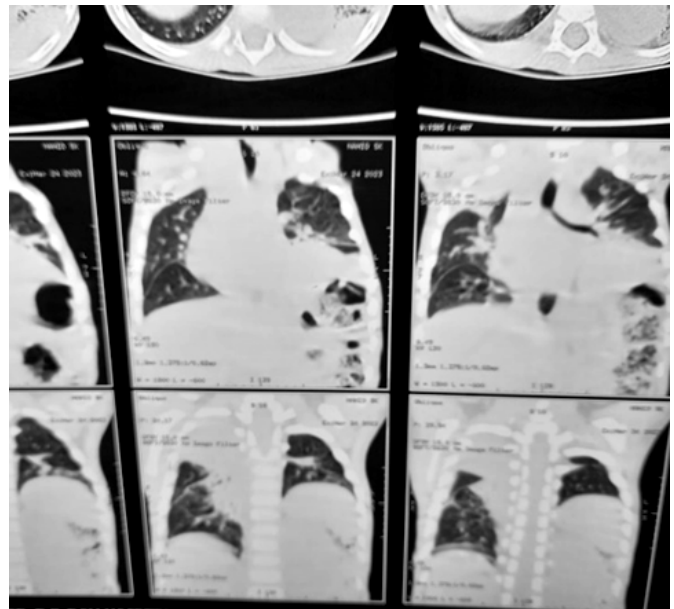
HRCT chest coronal section : Elevated left hemi diaphragm with few gas filled bowel loops beneath it
